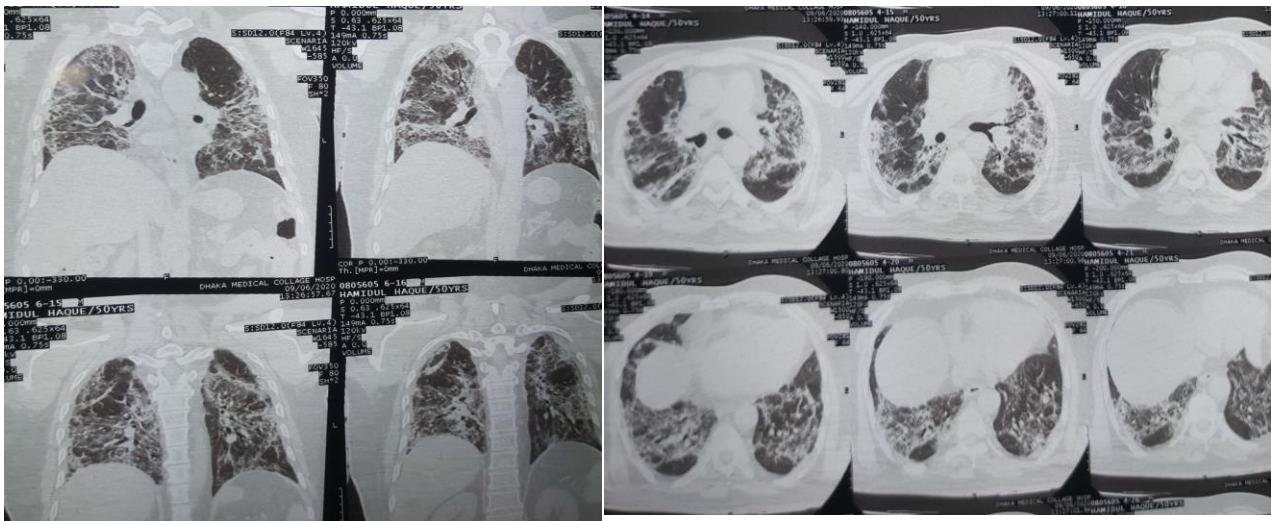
Figure IIIA and IIIB): Showing extensive bilateral pneumonia of both lungs on HRCT of chest of Case 2
